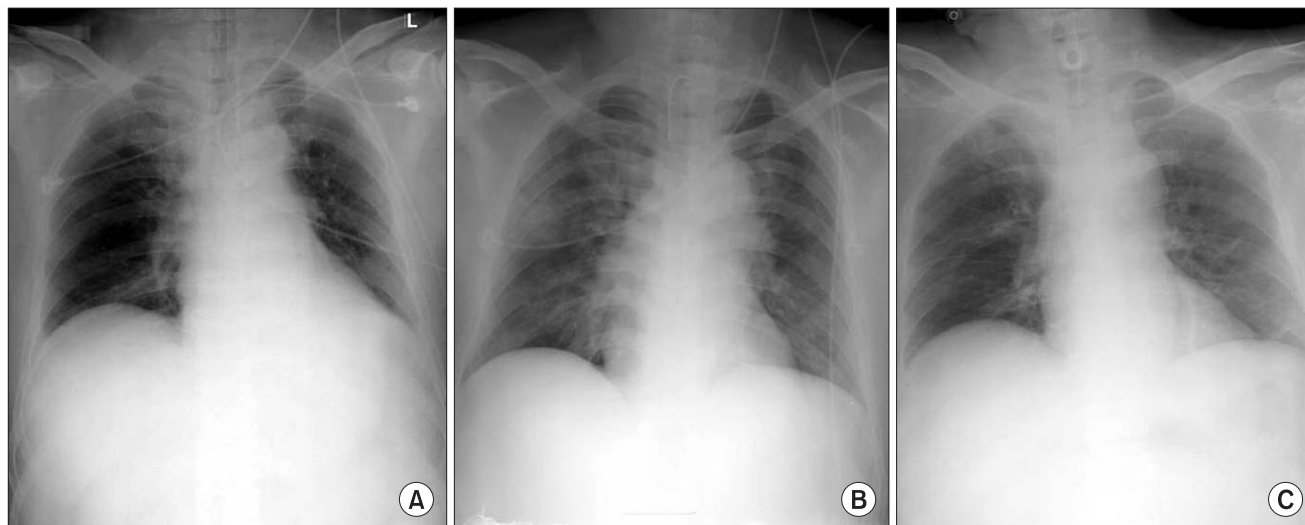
(A) Preoperative, (B) Postoperative, and (C) Follow up chest X-rays reveal unremarkable findings.
